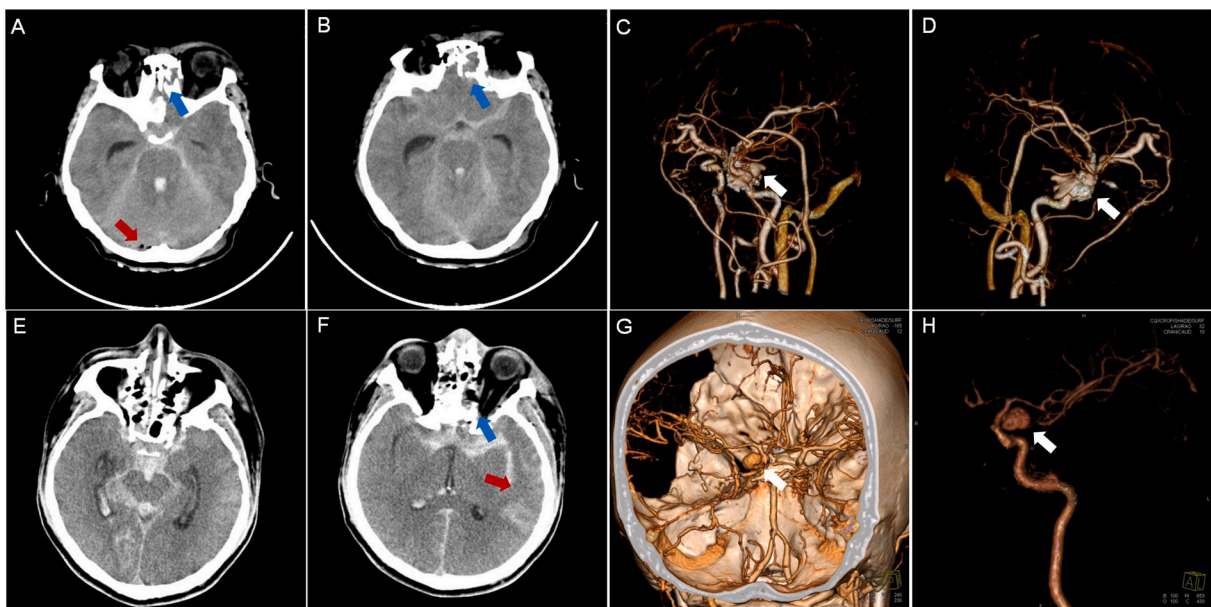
Representative neuroimages of traumatic subarachnoid hemorrhage (tSAH) patients with dual-source computed tomography angiography (DSCTA) scans. Case 1: CT scan showed the extensive SAH in the cistern of skull base (A and B; red arrow: intracranial pneumatosis; blue arrow: multiple skull fractures). Volume rendering images indicated the pseudoaneurysm combining of carotid artery cavernous sinus fistula CCF (C and D; white arrow). Case 2: CT scan showed the extensive SAH in the skull base as well as the contusion and laceration of temporal lobe. (E and F; red arrow: cerebral contusion and laceration; blue arrow: multiple skull fractures). Volume rendering images indicated the IA in posterior communicating artery (G and H; white arrow).
